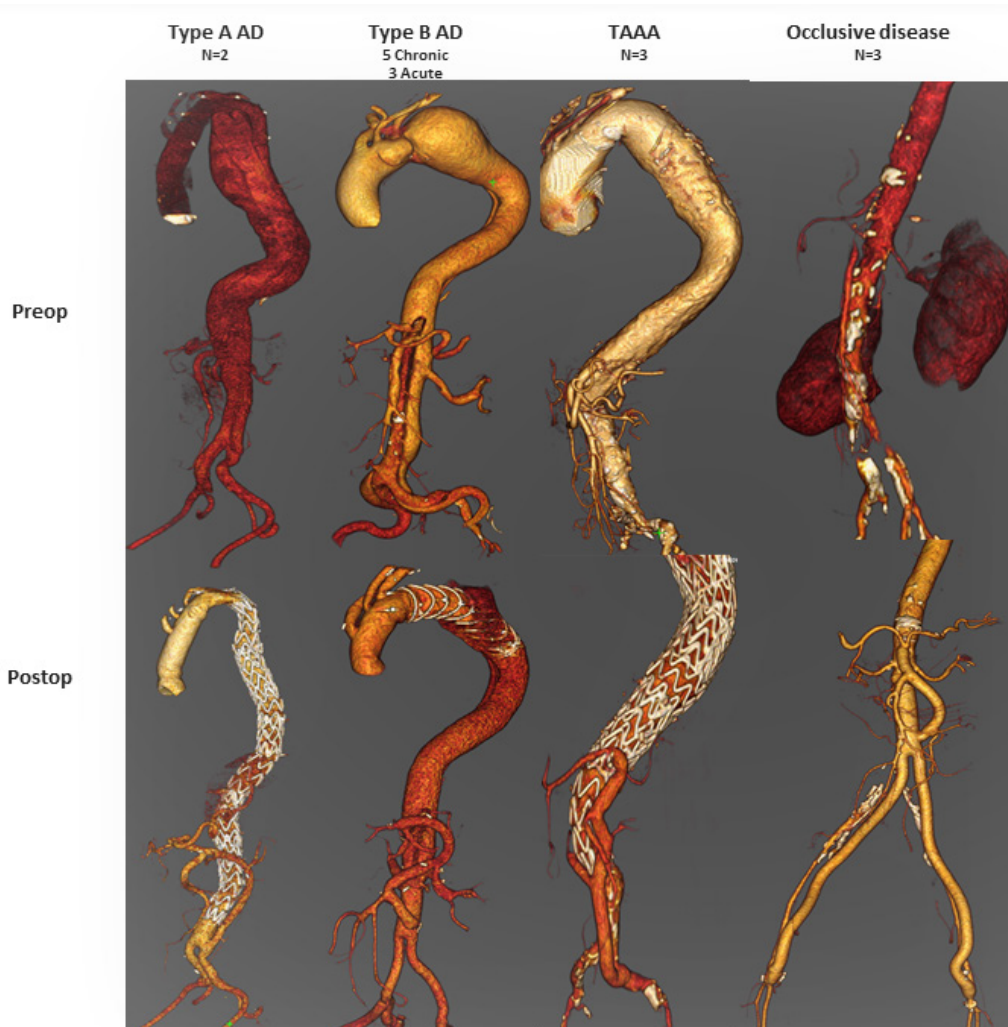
Representative preoperative and postoperative CT scan of the different categories of patients.
